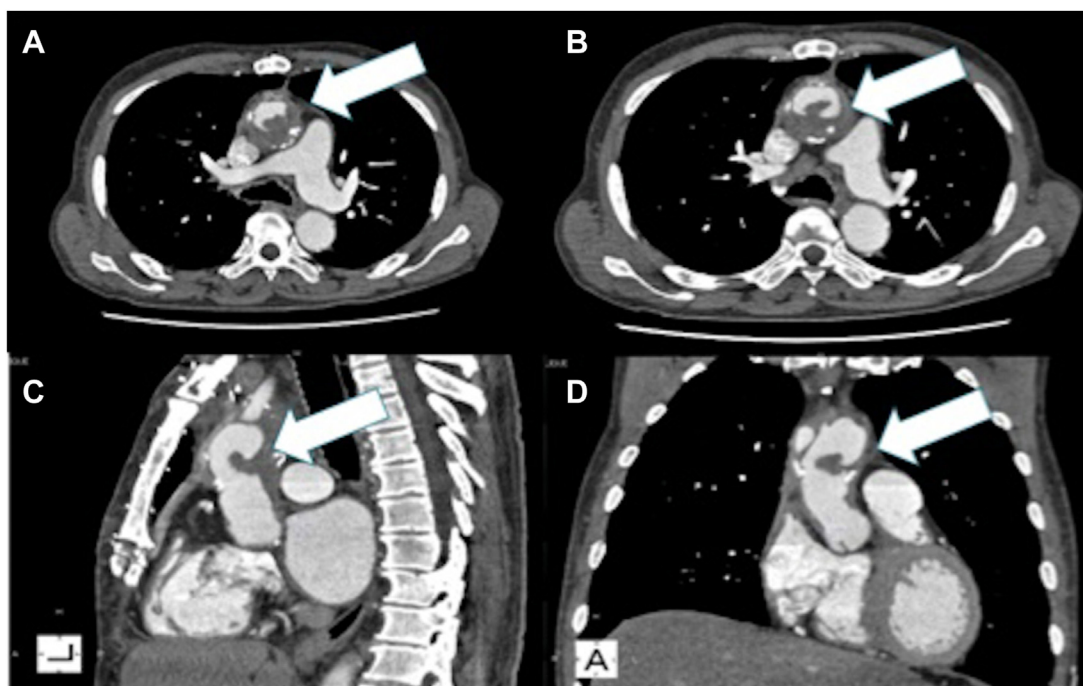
A contrast-enhanced computed tomography angiogram of the chest in (A, B) axial, (C) sagittal, and (D) coronal views shows a thrombus in the ascending aortic graft (arrows) (A, anterior view; L, lateral view.)
